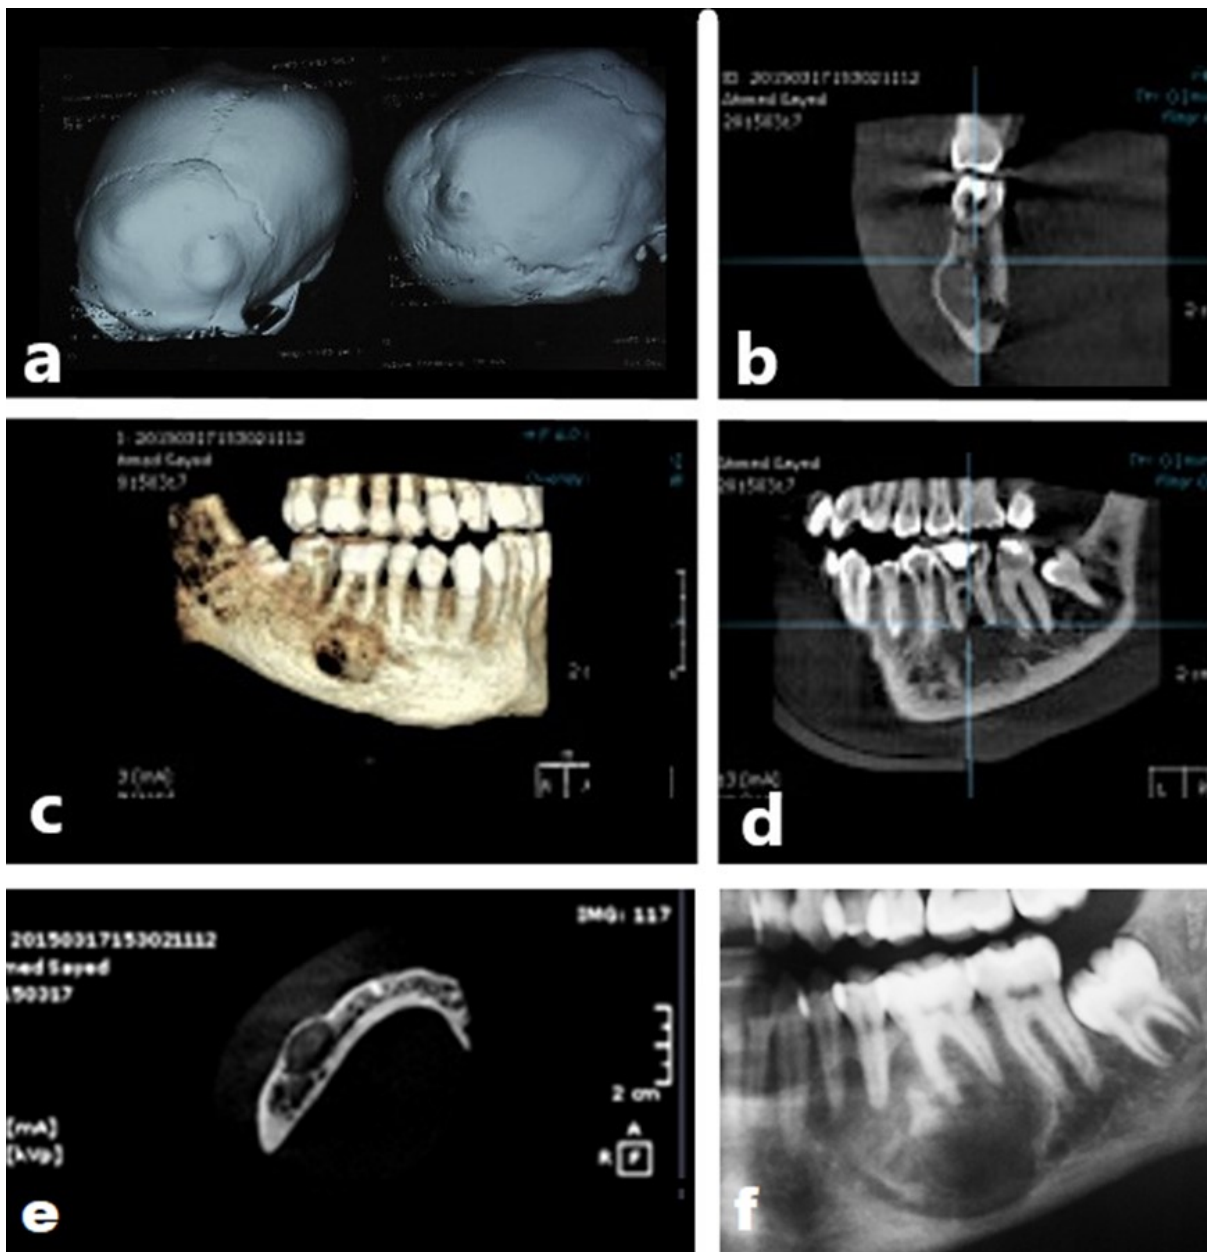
(a) A CT scan of the skull showing bony swellings in the frontal bones, the pterion and near the lambdoid suture; (b), (c) (d) and (e) CBCT cuts showing the lesion related to the lower left first molar and extending apically toward the lower border of the mandible; (f) Panoramic radiograph showing the lower left premolar-molar area where a radiolucent area with interrupted cortication and a radiopaque fragment inside.
